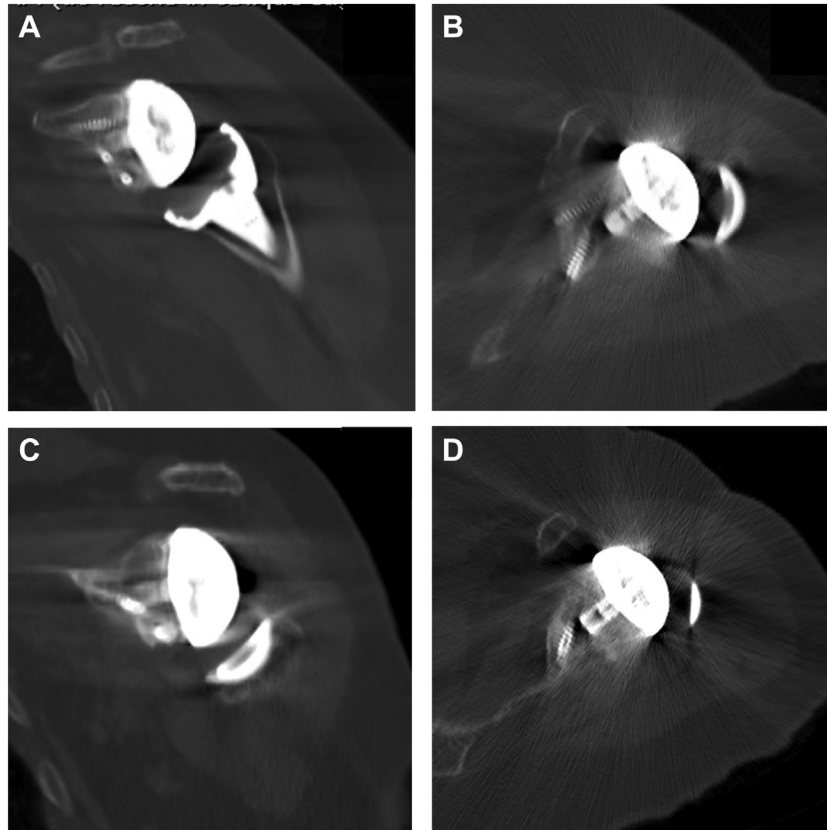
Six-month (A and B) and 2-year (C and D) CT scan with adequate bone graft osseointegration. The glenosphere is congruent and no lucencies are noted in both follow-up images. CT, computed tomography.
